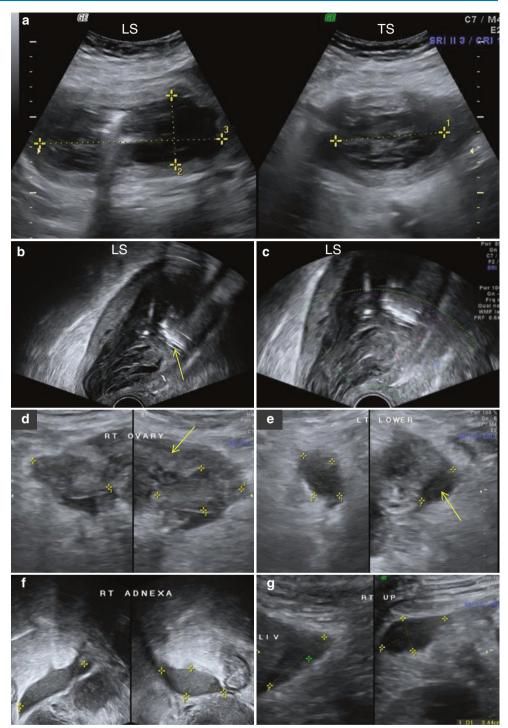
Pyometra in a patient with endometrial carcinoma. (a) Turbid complex fluid with air echoes is seen in the endometrial cavity, suggestive of pyometra with anaerobic infection. (b) Solid tissue (*arrow*) seen in the upper uterine cavity which showed flow on Doppler, suggestive of a neoplastic growth
